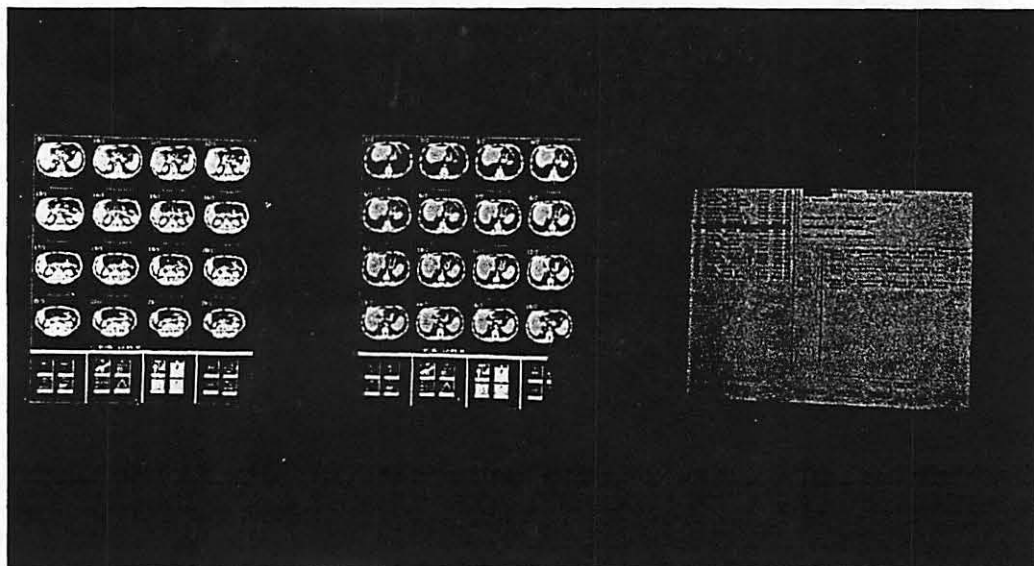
A diagnostic workstation with two 21-inch diagonal 2048 x 2560 portrait mode MegaScan monitors showing 16 CT scan images on each monitor. This workstation currently is used at the UCSF neuroradiology section.
